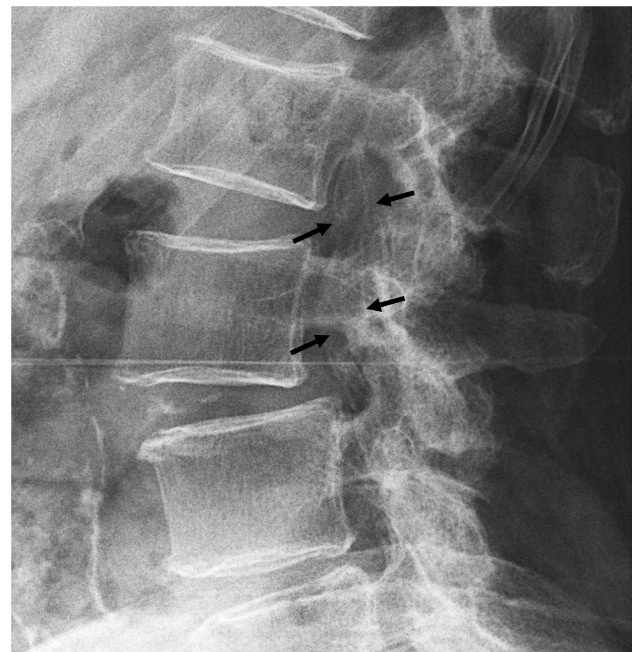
Lateral radiograph of the lumbar spine shows faint fusiform linear ossifications (arrows) projecting over the spinal canal
